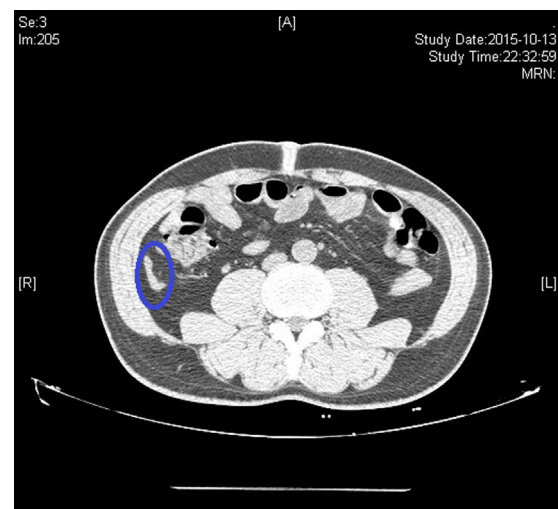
CT results of appendix.
